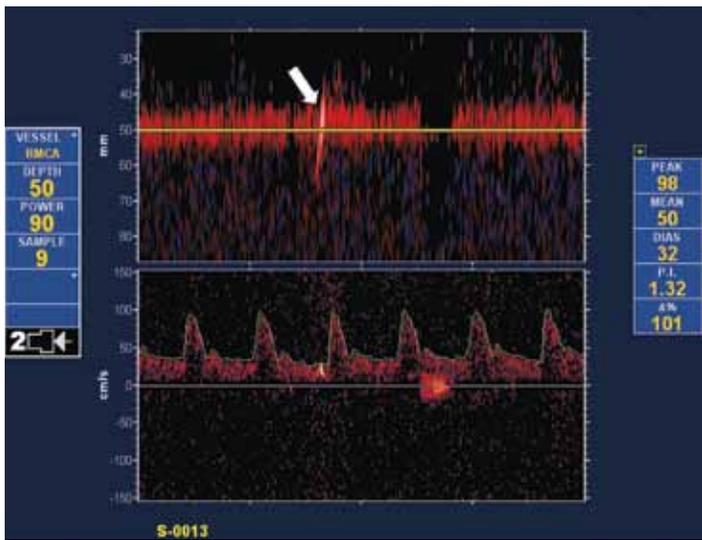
Transcranial Doppler results; microembolic signal detected on TCD screening. The right middle cerebral artery was monitored by TCD system for 15 minutes and captured 2 embolic signals. One of two emboli signals is indicated by a white arrow.
